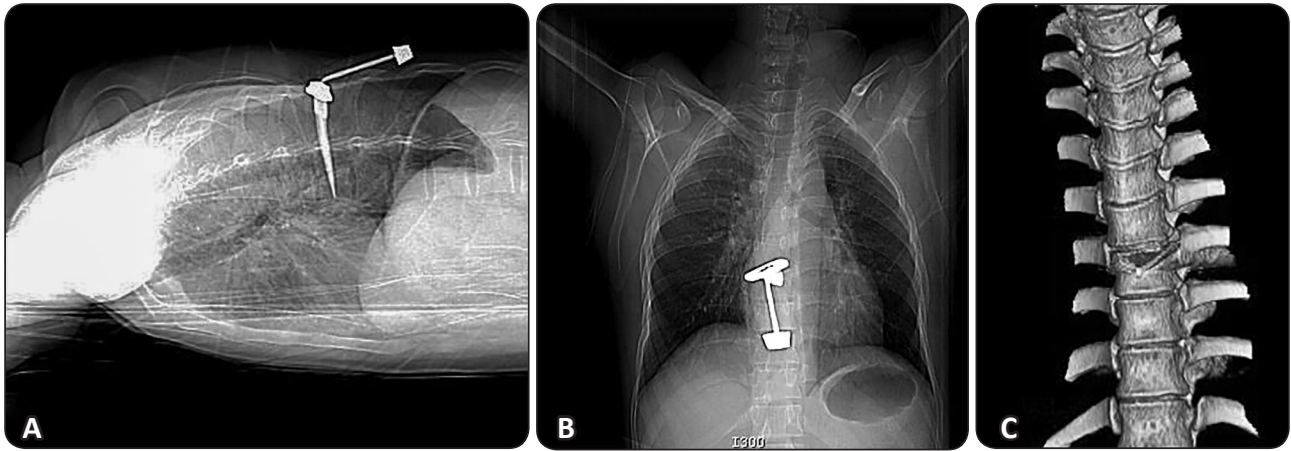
Showing A: lateral, B: X-ray and C: 3D CT-scan dorsal spine stabbed with knife. He was male patient, 26 years had knife stab wound in the dorsal region with incomplete spinal cord injury with paraparesis Frankel (C), Surgical exploration was done and the knife tip was extracted and the patient improved 3 months postoperatively to Frankel (D).
